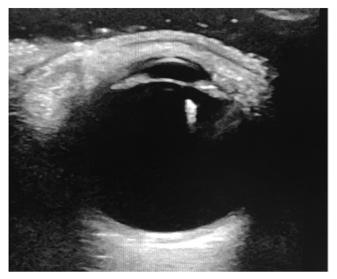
Post-removal ultrasonography of the left eye showing only the echo of the foreign body left behind in the lens and no intravitreal foreign bodies.
